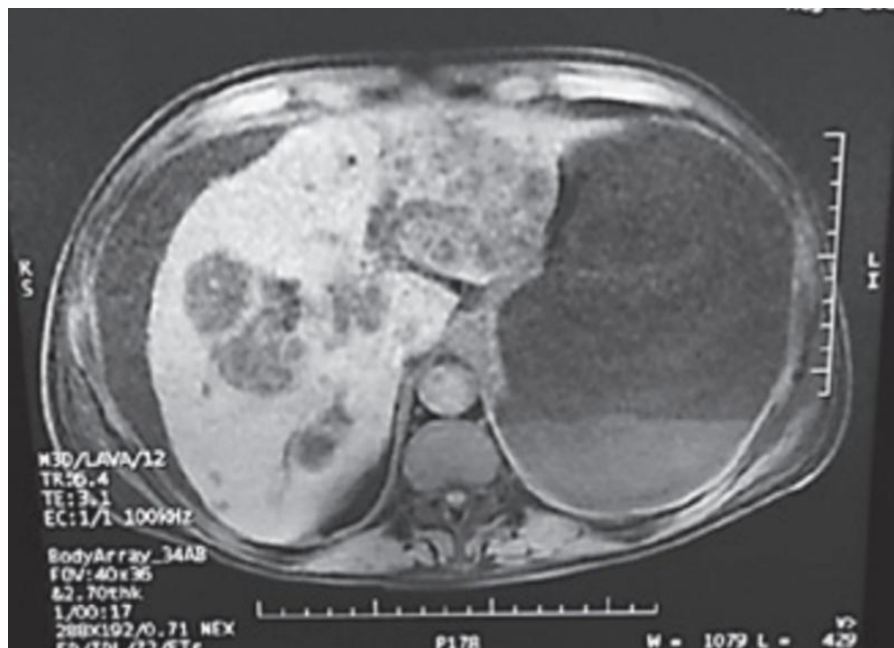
Abdominal CT scan, with arrow highlighting liver lesion.
